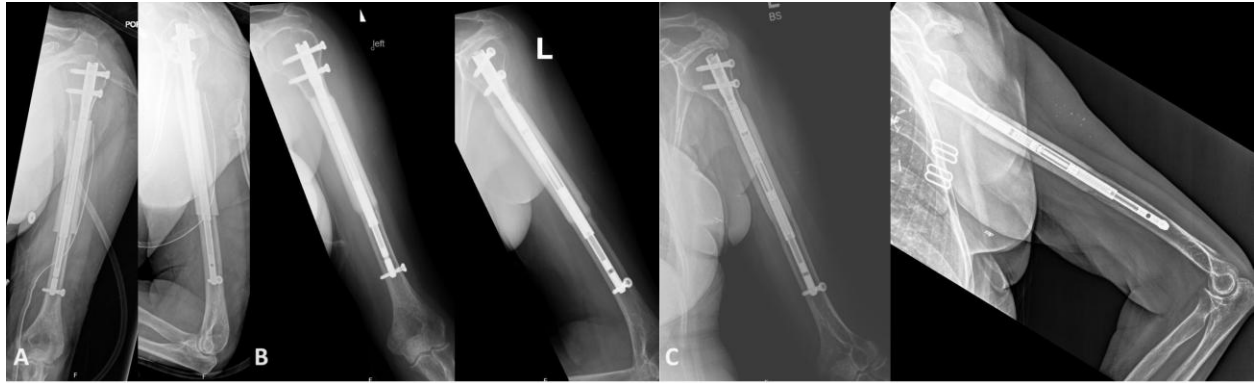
A) AP and lateral humeral radiographs of a 58-year-old female who actively smokes 1/2 pack per day with oligometastatic breast cancer. The patient underwent resection with intercalary allograft reconstruction and underwent routine compression post-operatively. B) AP and lateral radiographs 6 weeks after surgery demonstrating healing of the osteotomy sites and incorporation of the allograft. C) AP and lateral radiographs 4 months after surgery demonstrating continued incorporation and remodeling at the osteotomy sites.
